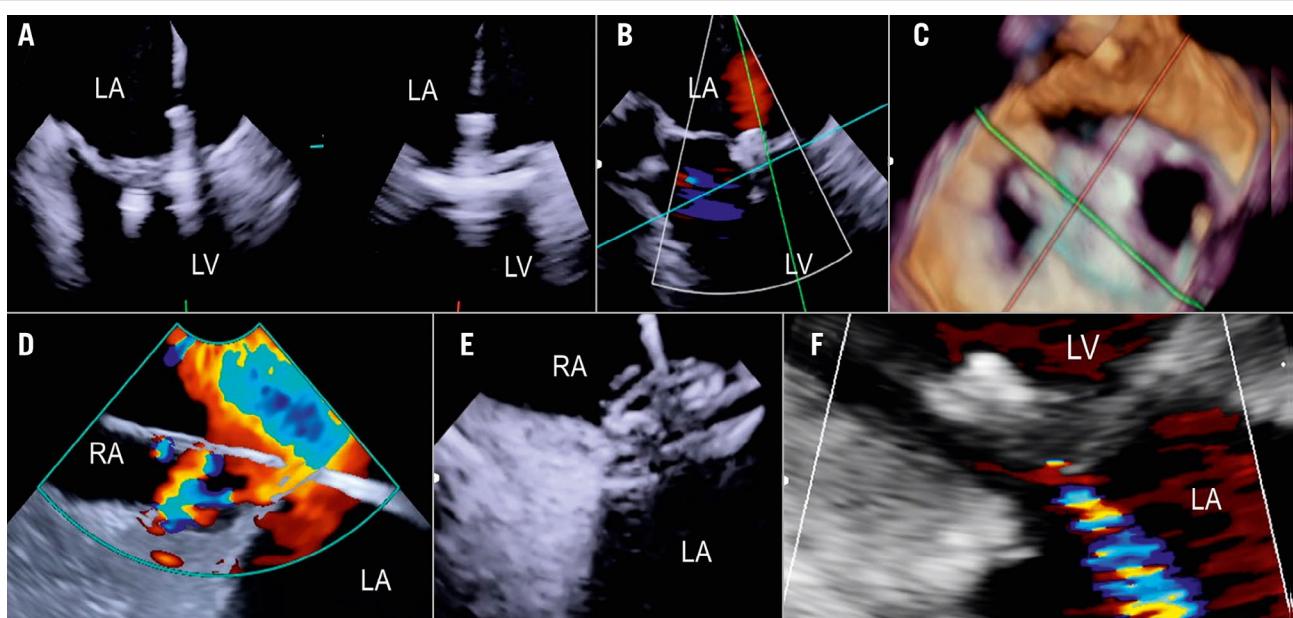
ICE-guided mitral valve transcatheter edge-to-edge repair. A) Implantation of two clips and leaflet capture under ICE visualisation; (B) final result after implantation of two clips for correction of a posterior flail; (C) 3D ICE view of the MV after implantation of two clips; (D) large iatrogenic ASD visualised from the right atrium and crossed by a wire; (E) ASD closure using a 14 mm Amplatzer Septal Occluder under ICE guidance; (F) final result with mild residual MR as shown by transthoracic echocardiography at discharge. 3D: three-dimensional; ASD: atrial septal defect; ICE: intracardiac echocardiography; LA: left atrium; LV: left ventricle; MR: mitral regurgitation; MV: mitral valve; RA: right atrium; RV: right ventricle
